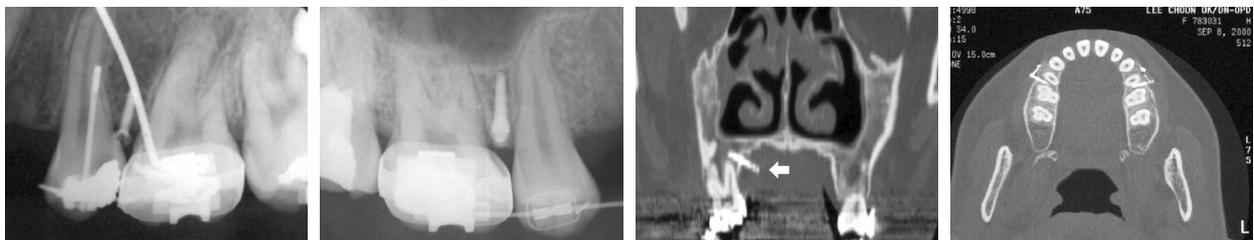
Review root approximation by microimplant with a periapical radiograph or CT scan.
